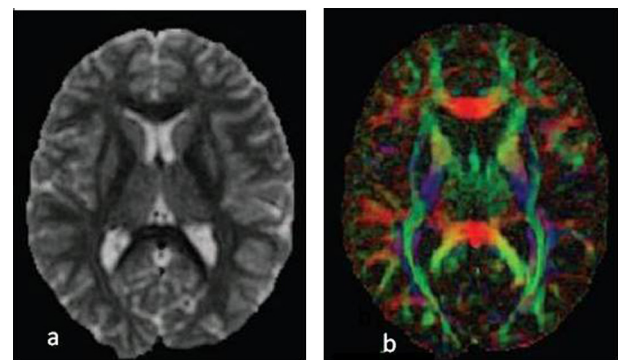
Images in 37 years old female healthy control subject (a) conventional MRI T2WI shows normal periventricular WM (b) color map to identify specific WM tracts with red–green–blue color (red fibers with lateral orientation: green antero-posterior: blue, craniocaudal).
